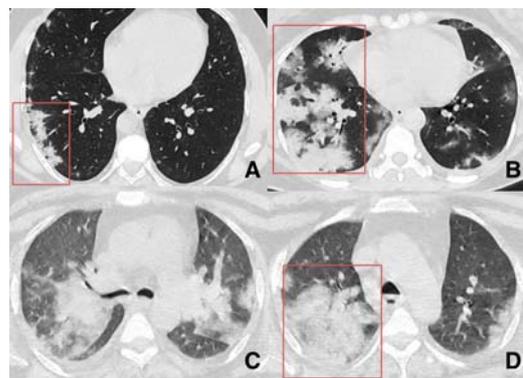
Chest CT axial images from three different patients of COVID-19, showing consolidation as the predominant pattern of involvement (red box). Notice the peripheral distribution of disease in A and peribronchovascular distribution in other cases. In the third patient (C, D) there are large confluent areas of consolidation in the central aspect of the lungs.
